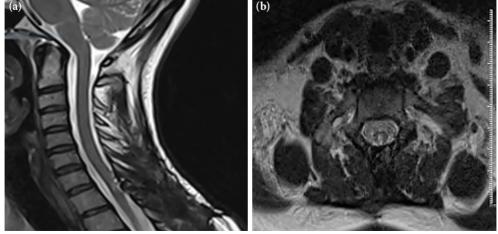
(a) Sagittal and (b) axial sections of postoperative cervical MRI of the patient following ependymoma resection.
